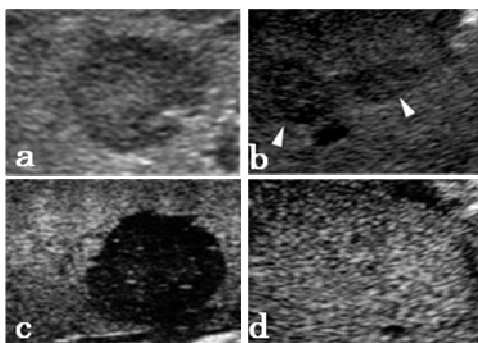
The ultrasonographic and sonazoid-enhanced ultrasonographic findings of malignant and benign lesions.
